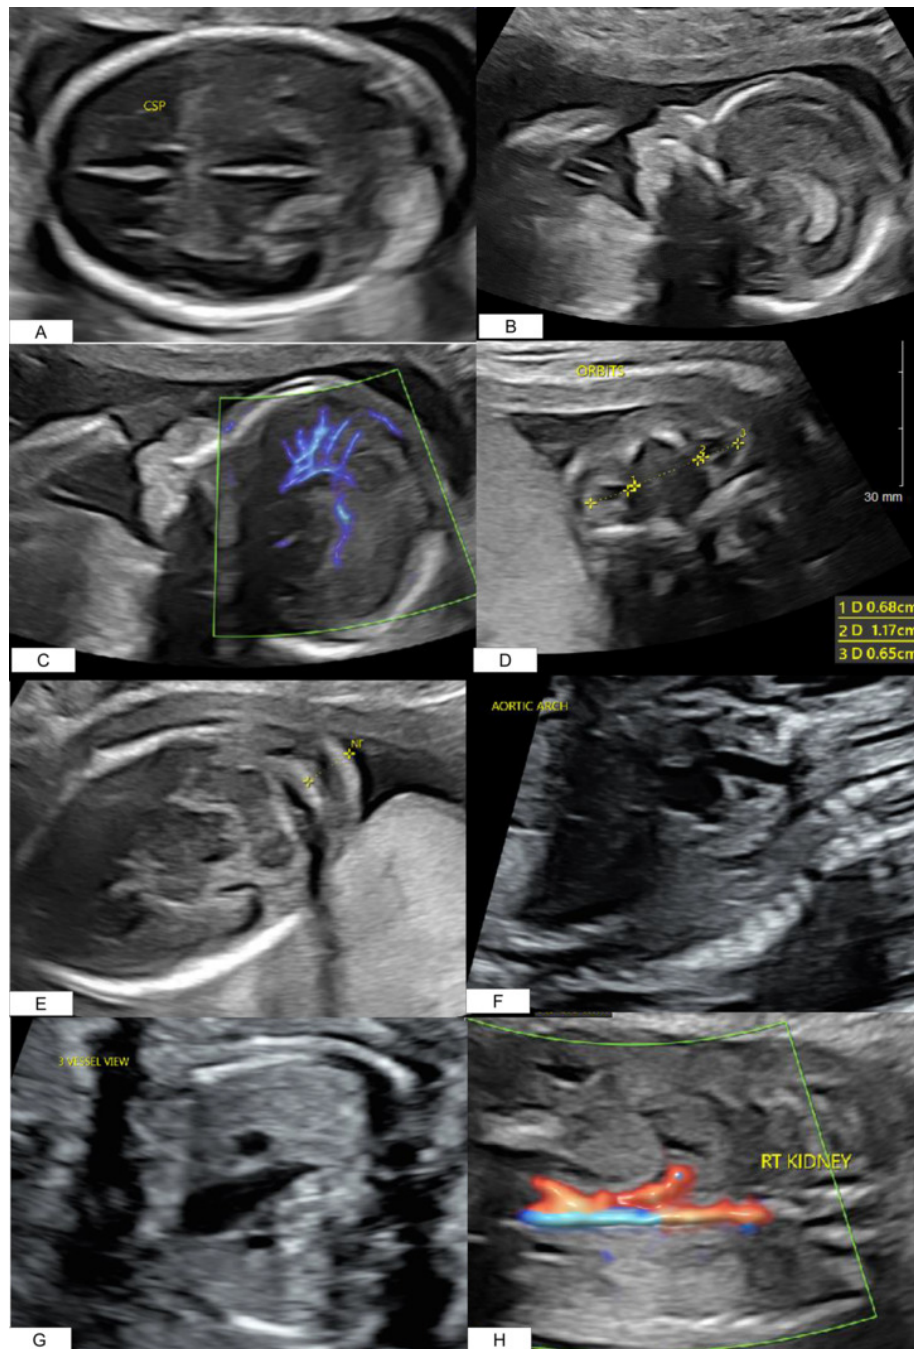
Ultrasound images from anatomy ultrasound at 20 weeks.
